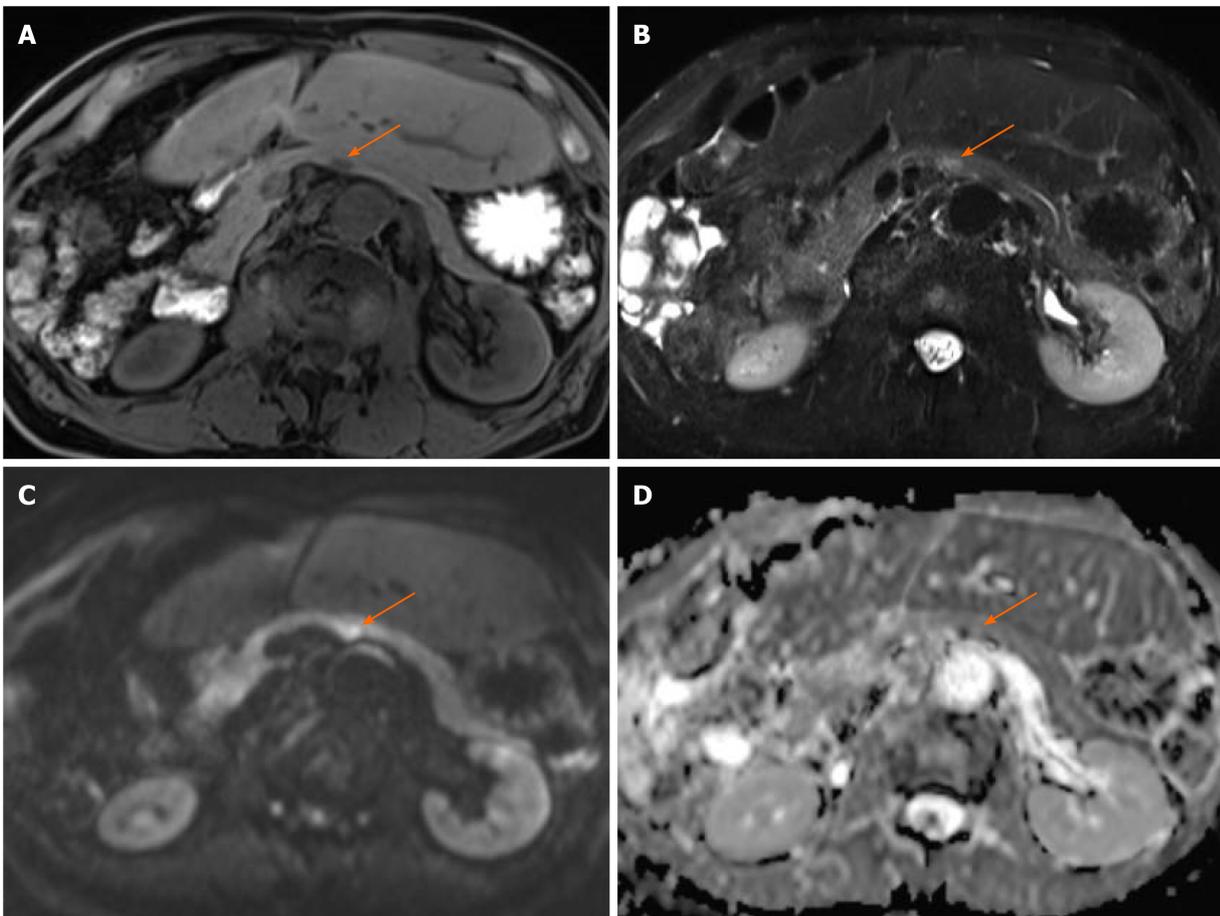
Magnetic resonance cholangiopancreatography images. A: The tumor showed low intensity in T1-weighted images (orange arrowhead); B: The tumor showed moderately high intensity in T2-weighted images (orange arrowhead); C: The tumor demonstrated high signal in diffusion weighted images (orange arrowhead); D: The tumor showed almost the same isodensity in an apparent diffusion coefficient-map phase (orange arrowhead).
